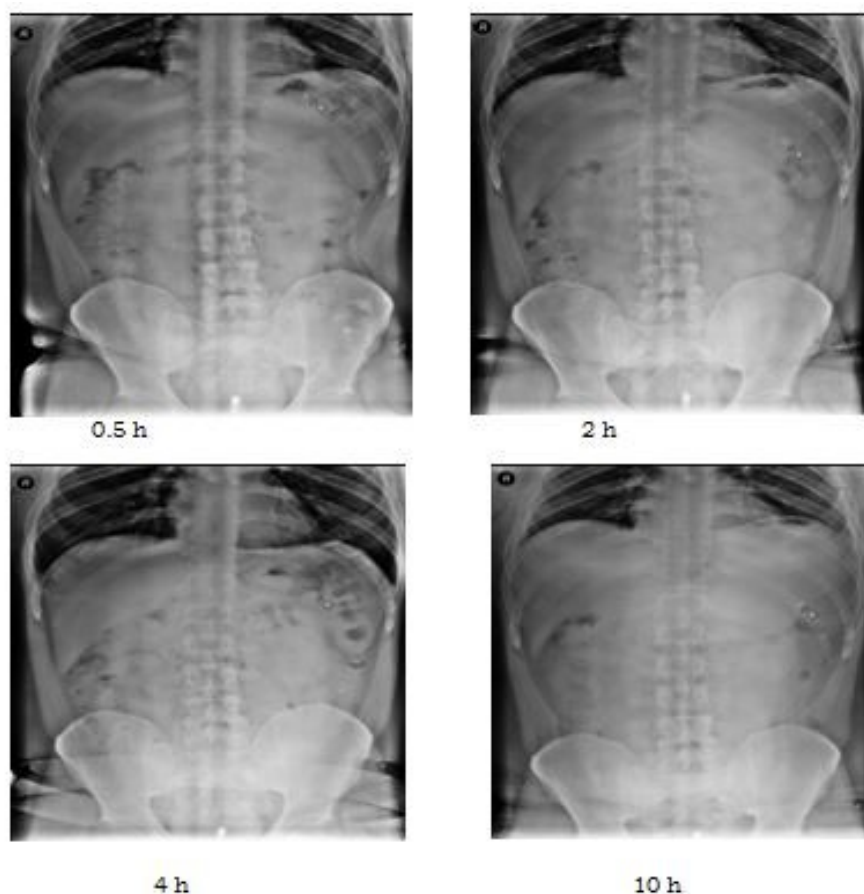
9 Radiographic Images of a BaSo<sub>4</sub> loaded rebapimide mucoadhesive tablet (F 13) in the stomach
